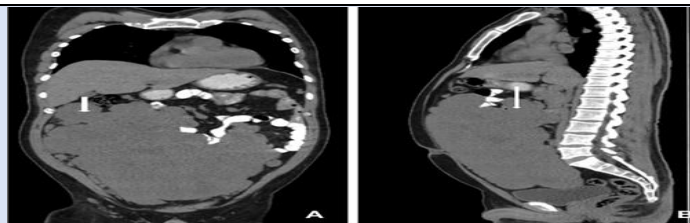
(A and B) omental GIST in a 42-year-old male patient who came with complaints of abdominal distension for 2 months. CT abdomen plain coronal (7A) and sagittal (7B) images show large well defined lobulated intraperitoneal soft tissue density mass along the anterior abdominal wall and mesentery extending from the epigastrium to the pelvis, abutting the hepatic flexure of colon proximal sigmoid colon with no obvious involvement. No evidence of bowel dilatation was noted.
